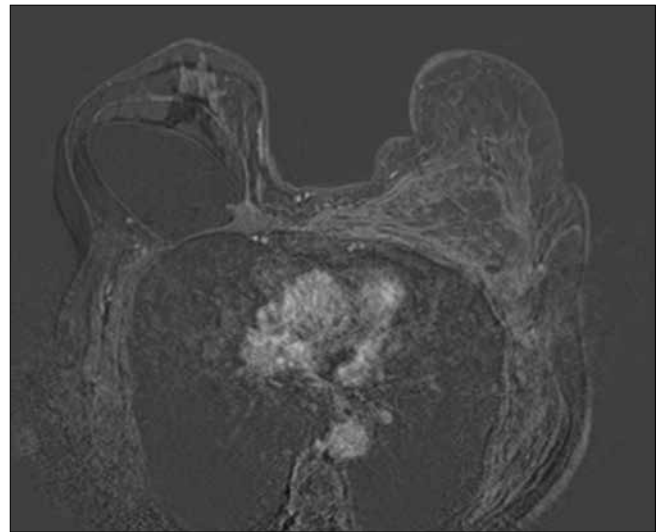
Axial post-contrast subtracted MRI image shows that the pectoral muscle and surrounding breast tissue showed heterogeneous early and delayed enhancement
